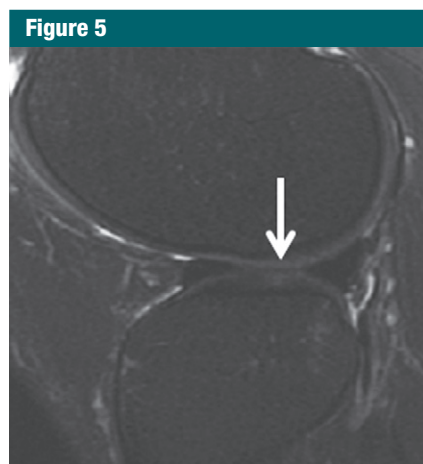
Images in 40-year-old man with arthroscopically normal articular cartilage on lateral femoral condyle (classified as MR grade 1A cartilage lesion). (a) Sagittal fat-suppressed T2-weighted fast spin-echo image shows normal-appearing articular cartilage on lateral femoral condyle (arrow). (b) Corresponding sagittal T2 map shows area of increased T2 relaxation time on lateral femoral condyle (arrow).
